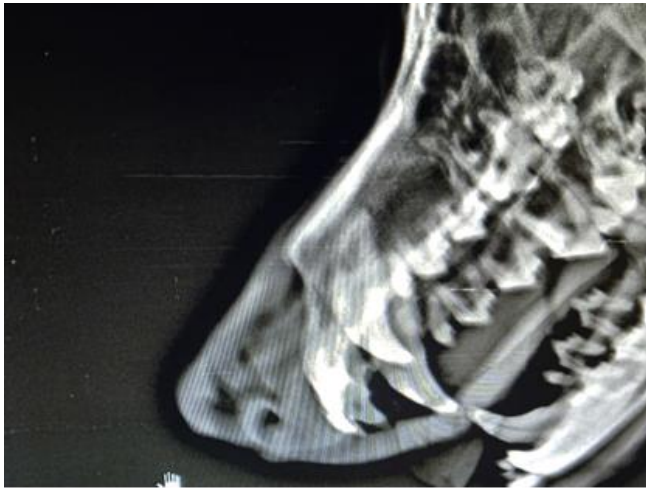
Radiographic view of right lateral head region showing salivary mucocele
